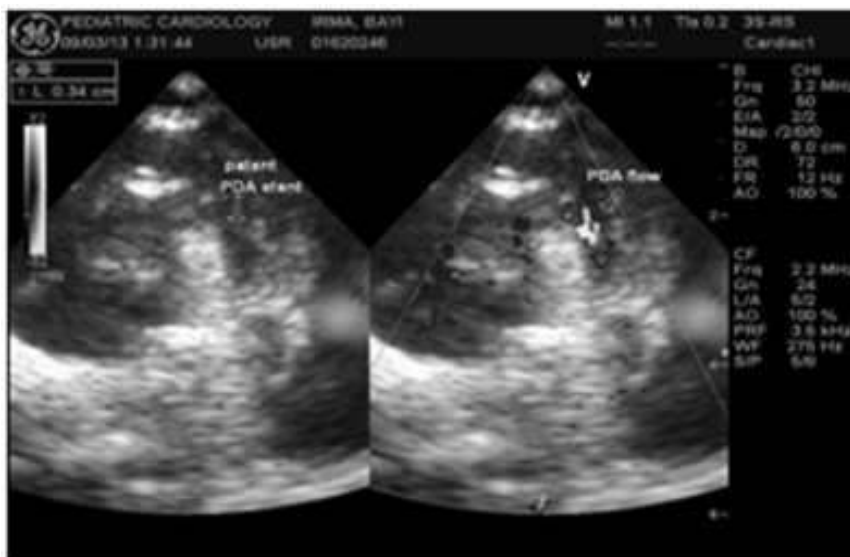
Echocardiography evaluation showed patent stent.
